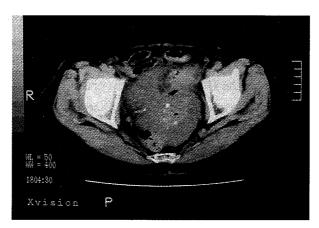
Enhanced computed tomography (CT) scan of the abdomen revealed sigmoid diverticula with a thickened wall, air bubbles in the uterine cavity and an abscess of Douglas pouch, due to diverticulitis. These findings suggested formation of a fistula between the sigmoid colon and uterine cavity.
